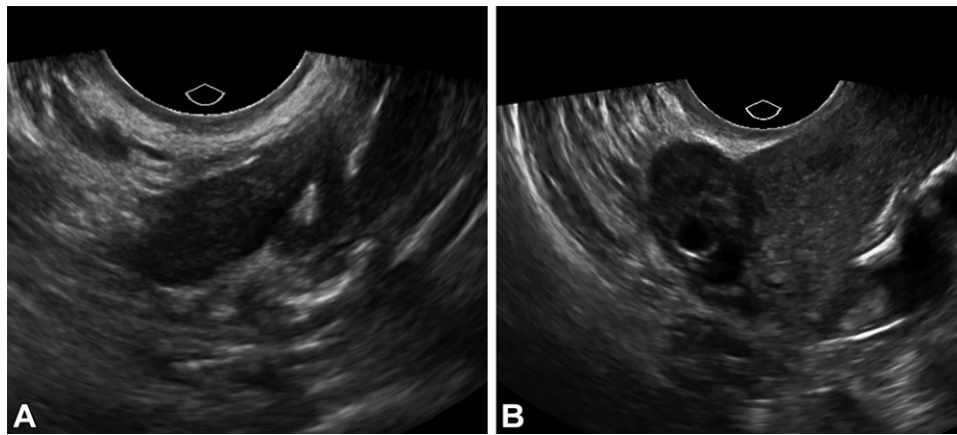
Normal gray-scale sonographic appearance of postmenopausal ovaries in a 57-year-old woman. (A) US image shows that the left ovary is atrophic and homogeneously hypoechoic and lacks follicles. (B) US image shows that the right ovary is atrophic, is slightly heterogeneous, and has an 8-mm cyst.
